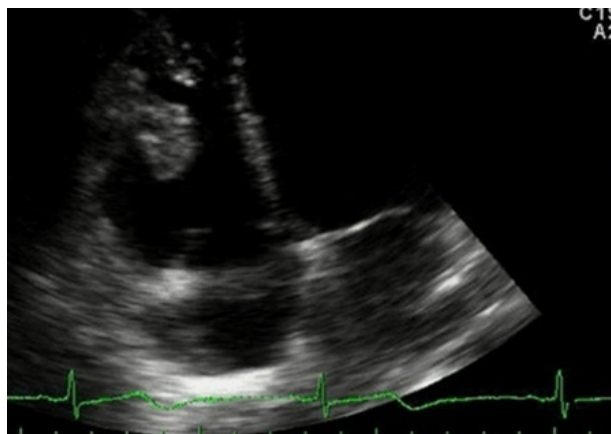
Post-chemotherapy transthoracic echocardiography: showed a decrease in the size of the right ventricular mass.
